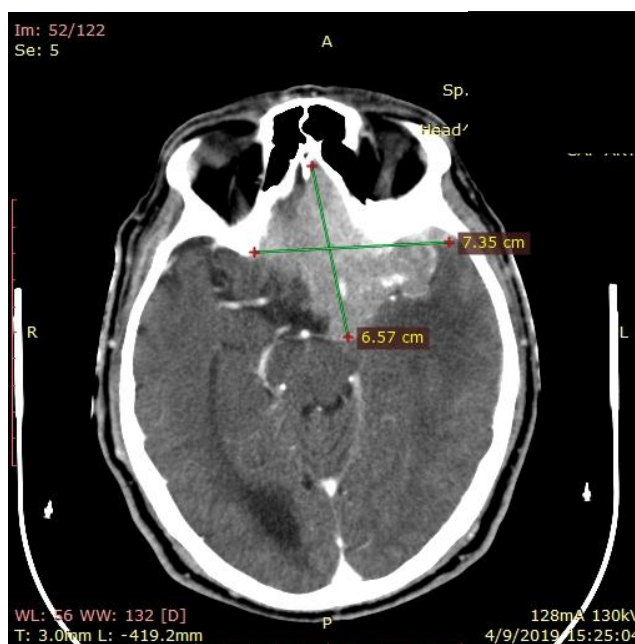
Craniocerebral CT with contrast substance examination
